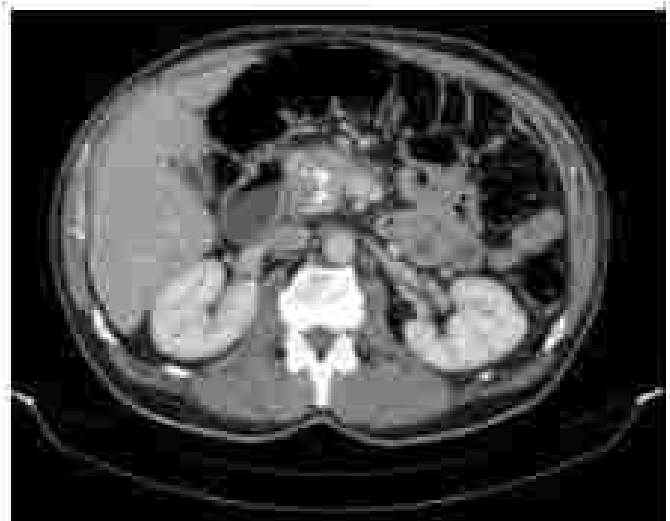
Computed tomography scan showing an enlarged pancreatic head with calcifications.
